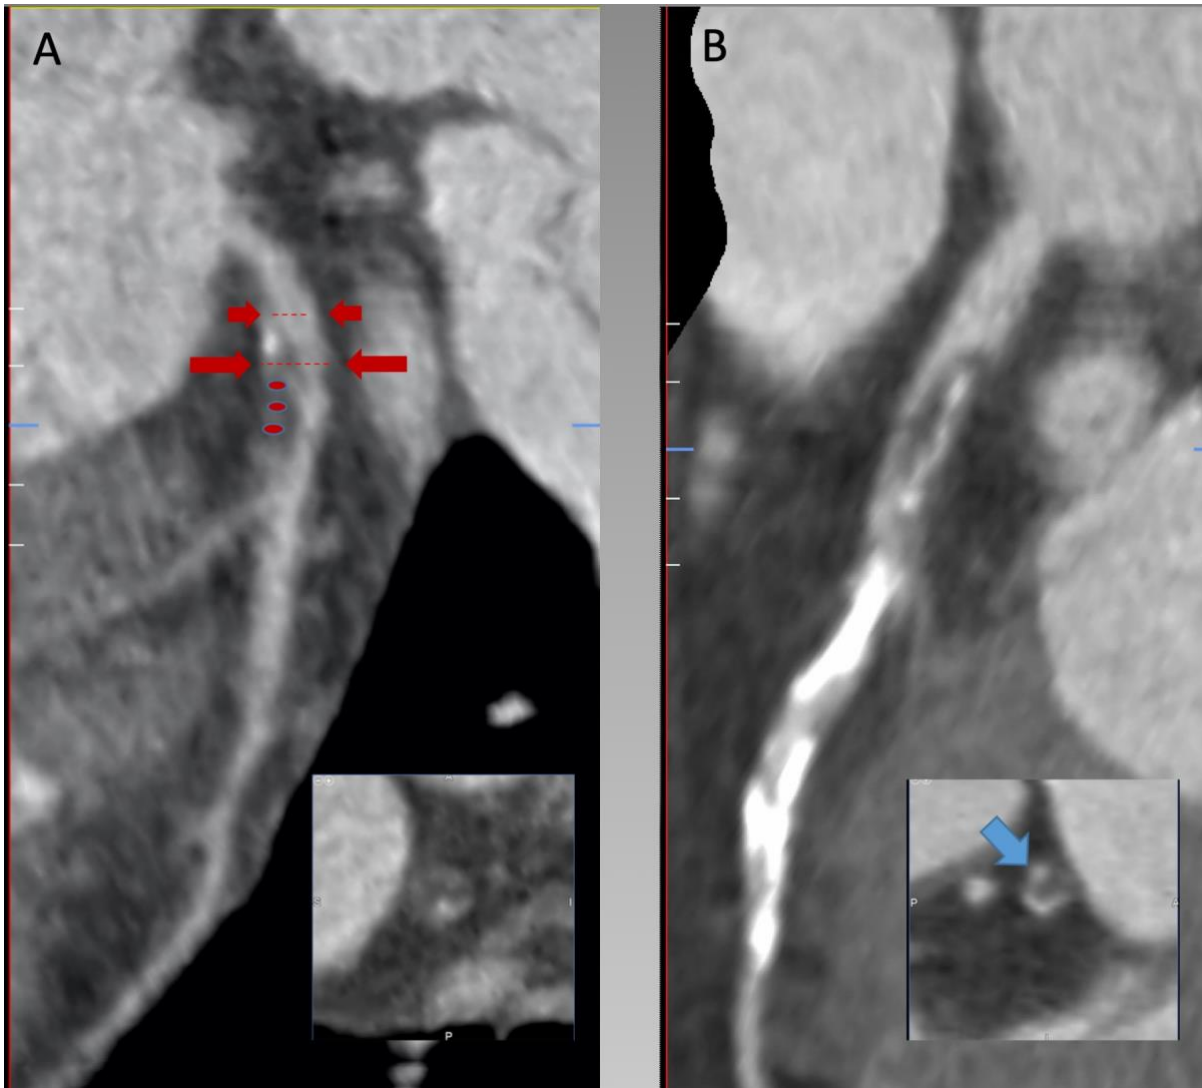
Atherosclerotic plaques showing CT features of vulnerability. A: An atherosclerotic plaque showing positive remodelling (red arrows) and low attenuation (red dots) plaque in the proximal left anterior descending artery on CCTA. B: An atherosclerotic plaque showing a Napkin ring sign in the right coronary artery. Figure adapted from SALEM AM. et al. Characteristics of conventional high-risk coronary plaques and a novel CT defined thin-cap fibroatheroma in patients undergoing CCTA with stable chest pain.¹¹⁴
